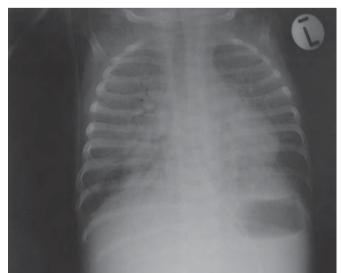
Radiologic progression of *Pneumocystis jiroveci* pneumonia (PCP) in an HIV-infected infant. A, initial radiograph and B, rapid progression of opacification within 24 hours.
